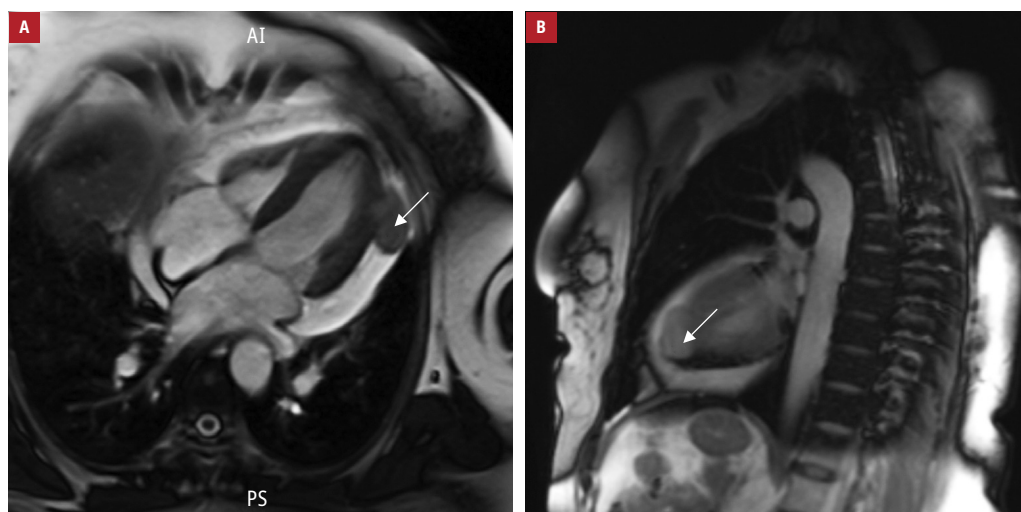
A – magnetic resonance imaging, transverse view (tumor indicated by the arrow); B – magnetic resonance imaging, longitudinal view (tumor indicated by the arrow)
